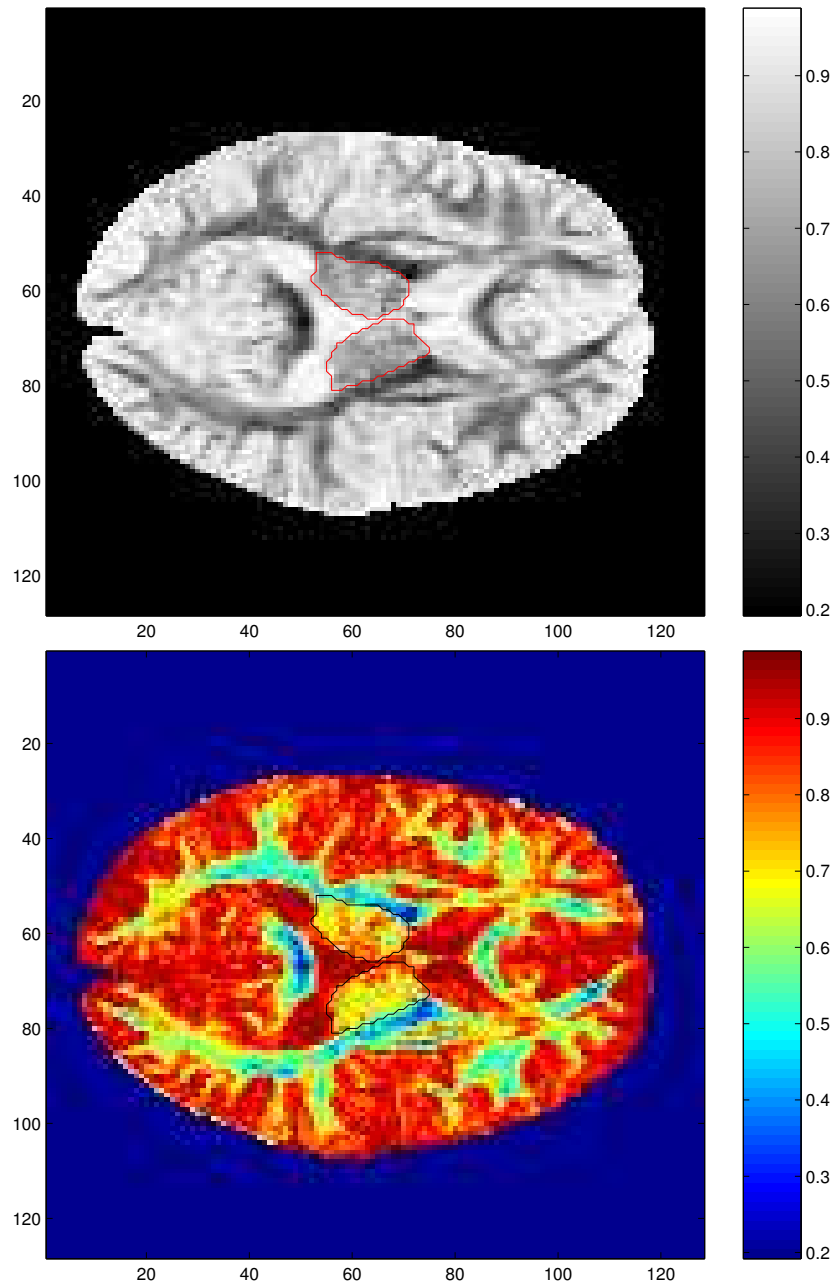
Spherical diffusion coefficient ( $c_s$ ) of a DT-MRI, axial slices. Same cut (slice #19) in black and white, and colours. The thalamus is the area inside the small contours, in the center of both images.
